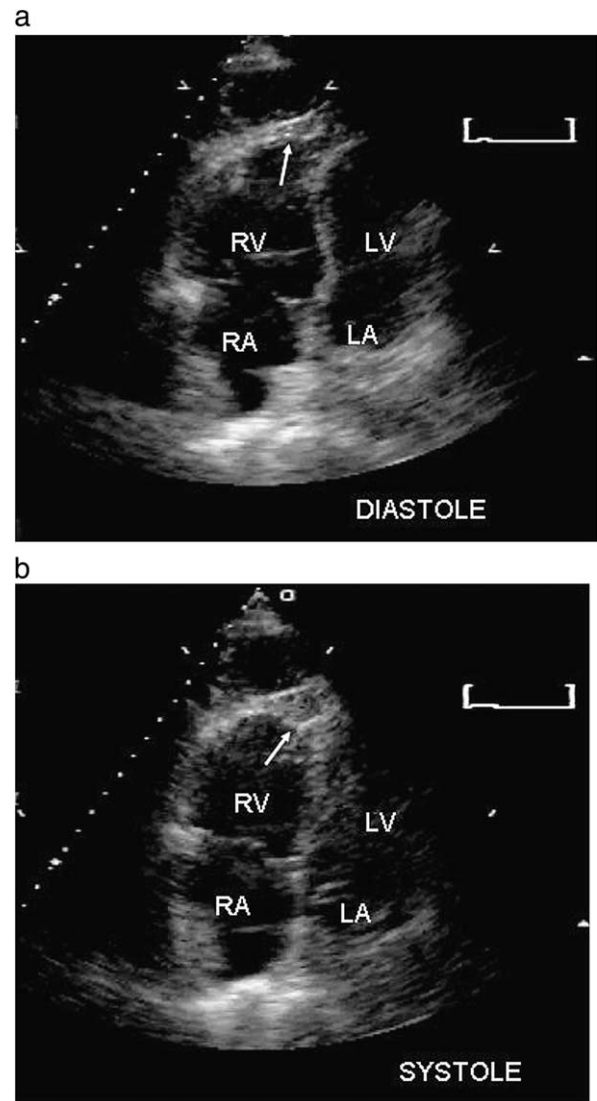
Echocardiographic 4-chamber views of a patient with massive pulmonary embolism and right ventricular dysfunction in end-diastole (a); and in end-systole (b). Arrows indicate normally contracting apical segments in a globally hypokinetic right ventricle (McConnell sign). RV, right ventricle; RA, right atrium; LV, left ventricle; and LA, left atrium.
